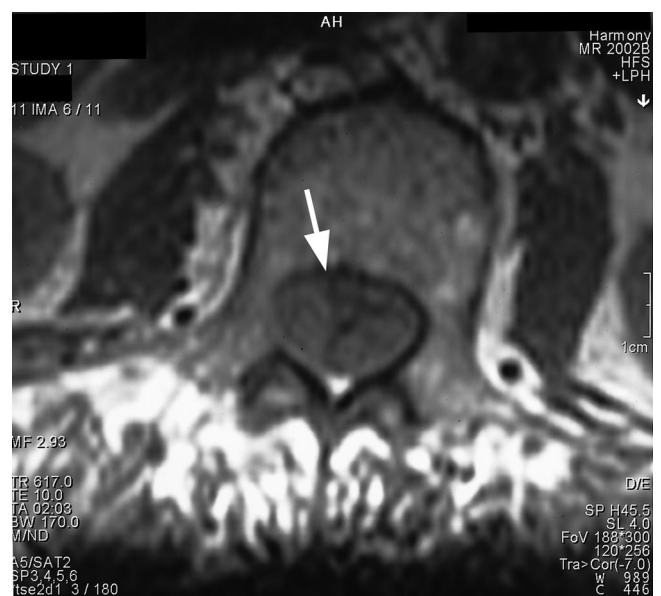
T1 axial magnetic resonance image showing the hematoma (L2).
